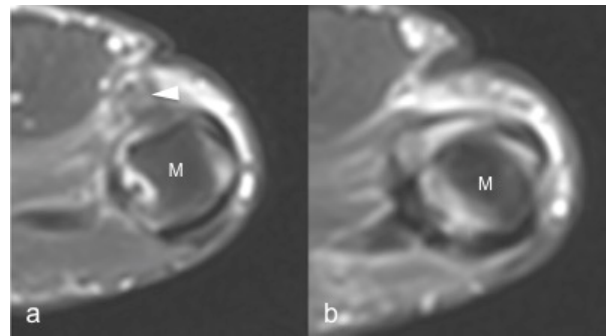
Same patient as in Figure 7. 1.5 T MRI shows a mass-like area (arrowhead) proximal to the joint representing the injured and displaced ligament in (a). In (b), the contralateral metacarpal phalangeal joint of the thumb. M: metacarpal head.
